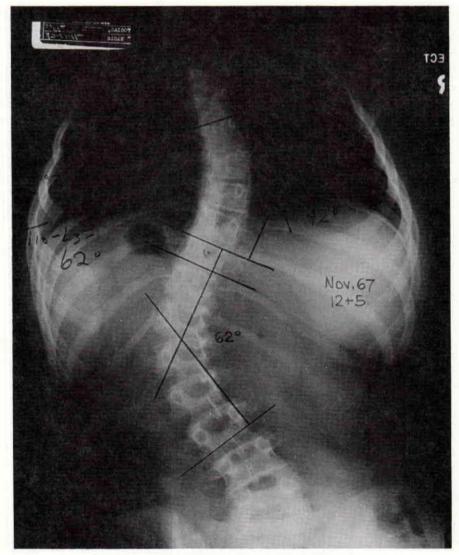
X-Ray of patient prior to application of localizer.
